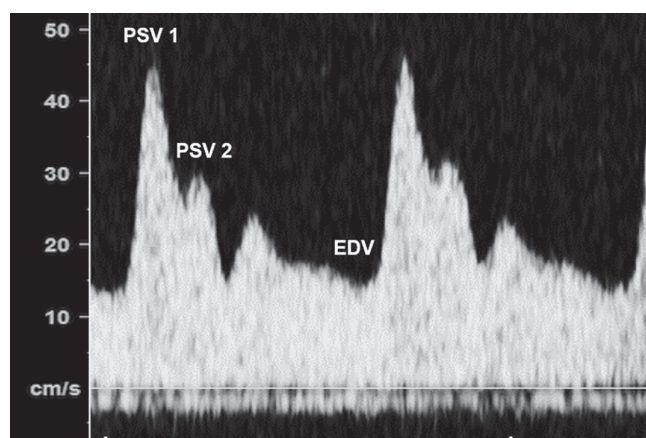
Flow velocity waveform from ophthalmic artery obtained by pulsed-wave Doppler, showing first (PSV1) and second (PSV2) peaks of systolic velocity and end-diastolic velocity (EDV).
